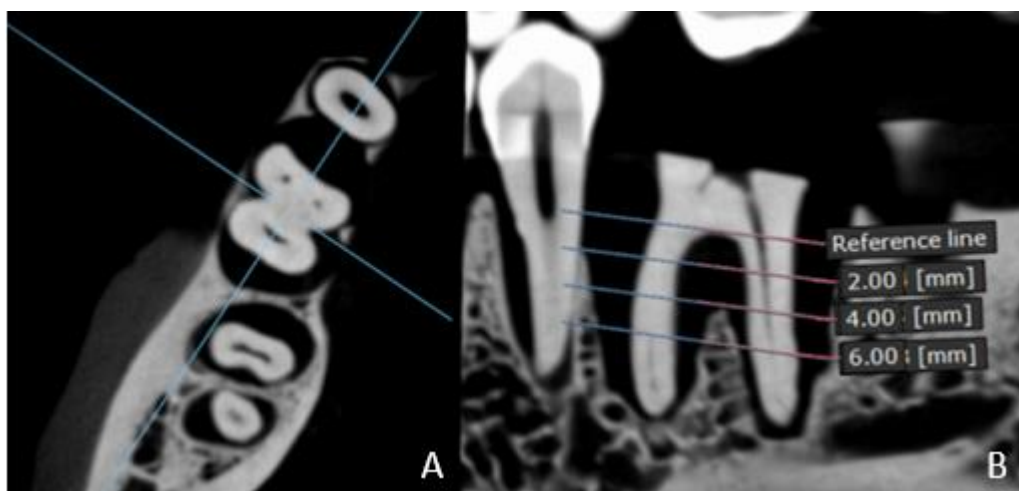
A) Axial CBCT reference section for the location of the sagittal section of the most central region of the root furcation. B) CBCT sagittal section showing the horizontal reference line tangent to the root furcation region; and lines parallel to the reference line, at 2-, 4- and 6
